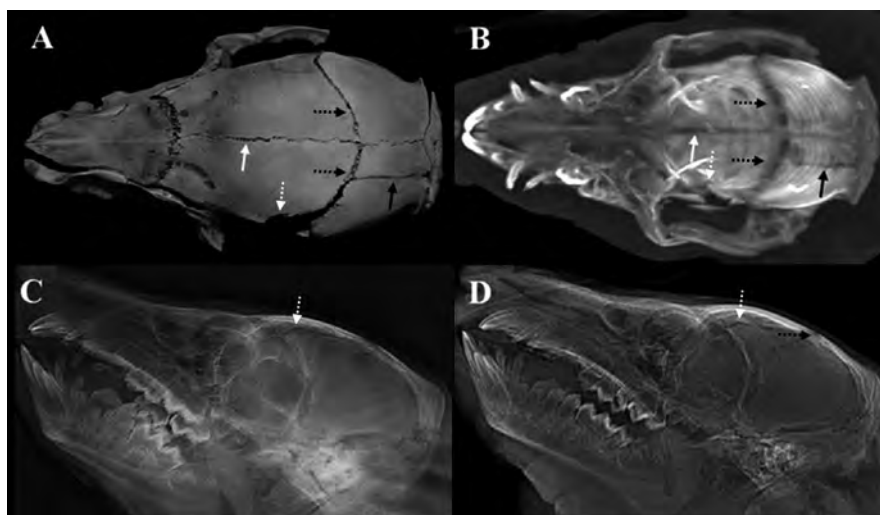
Parietal simple linear (solid black arrow) and sagittal diastatic fracture (solid white arrow) as seen on dry bone (A) and CT (B), but not visible on X-ray (C) or Lodox[®] (D) on any radiographic views. Frontal simple linear fracture (white dashed arrow) seen on dry bone (A) and all three imaging modalities (B–D), and coronal diastatic fracture (dashed black arrows) seen on dry bone (A), CT (B), and Lodox[®] (D), but not on X-ray (C)
